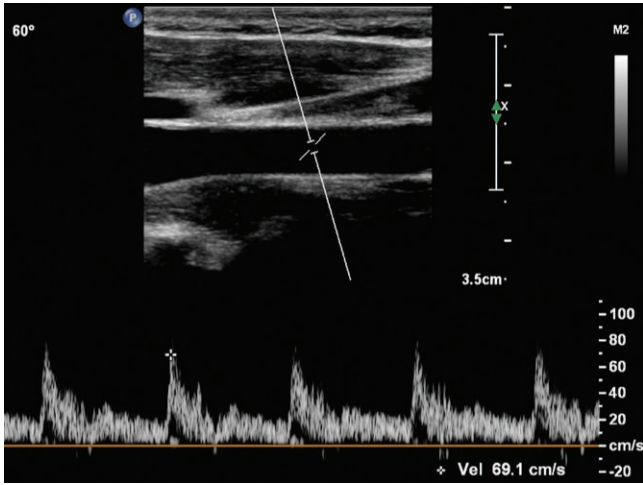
Spectral Doppler angle correction is incorrect. The angle is set at 60 degrees but it is not aligned to the walls of the vessel.
